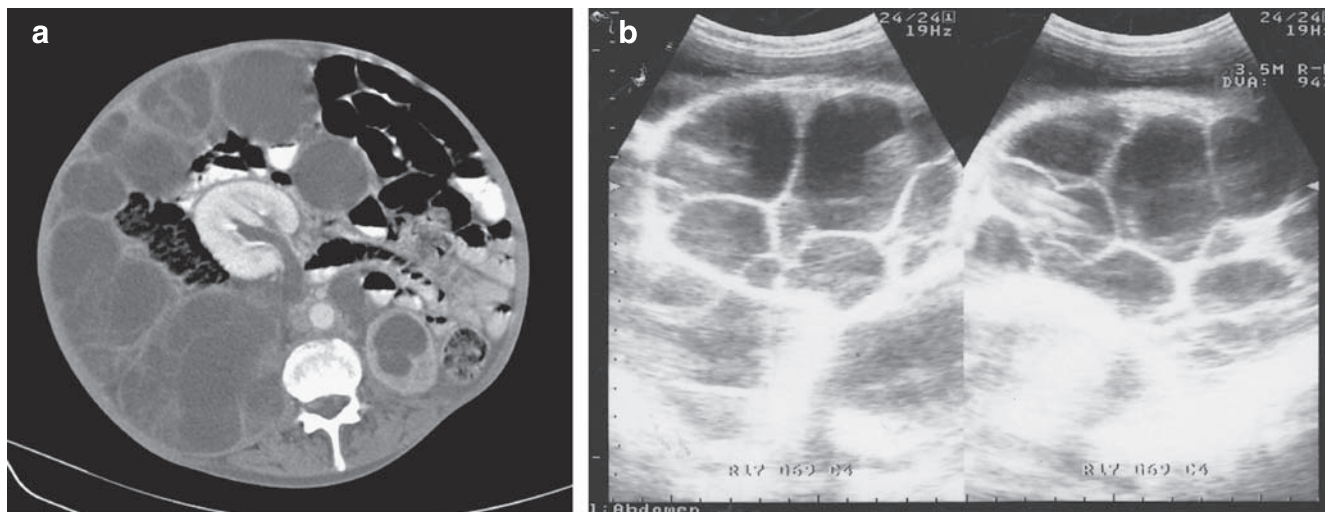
Disseminated abdominal, retroperitoneal, and pelvic hydatid disease. (a) The right kidney is pushed to the midline and the left kidney is hydronephrotic and shrunken by retroperitoneal hydatid cysts. (b) Ultrasound of the abdomen showing cystic lesions in the retroperitoneum in the position of the kidneys.
